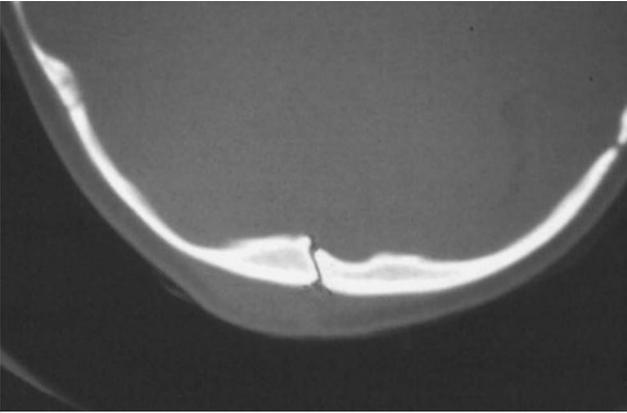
A computed tomographic scan (bone algorithm) immediately below the inion demonstrating a small tract extending through the outer and inner tables of the skull.
